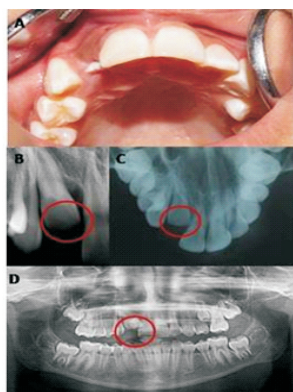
A. Intraoral photograph after 10 days showing spontaneous eruption of 12. B, C & D. IOPA, occlusal radiograph and OPG depicting total removal of the odontome.
